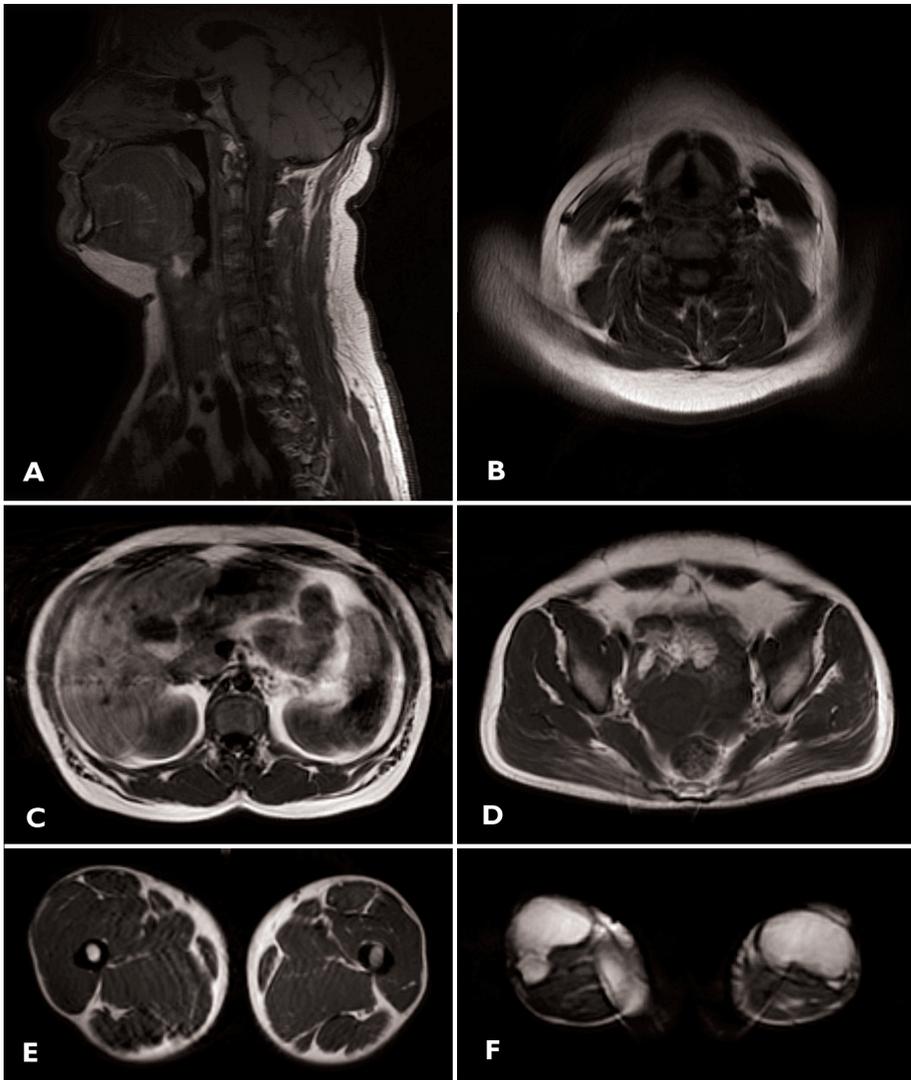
Magnetic resonance imaging (MRI) scans.
